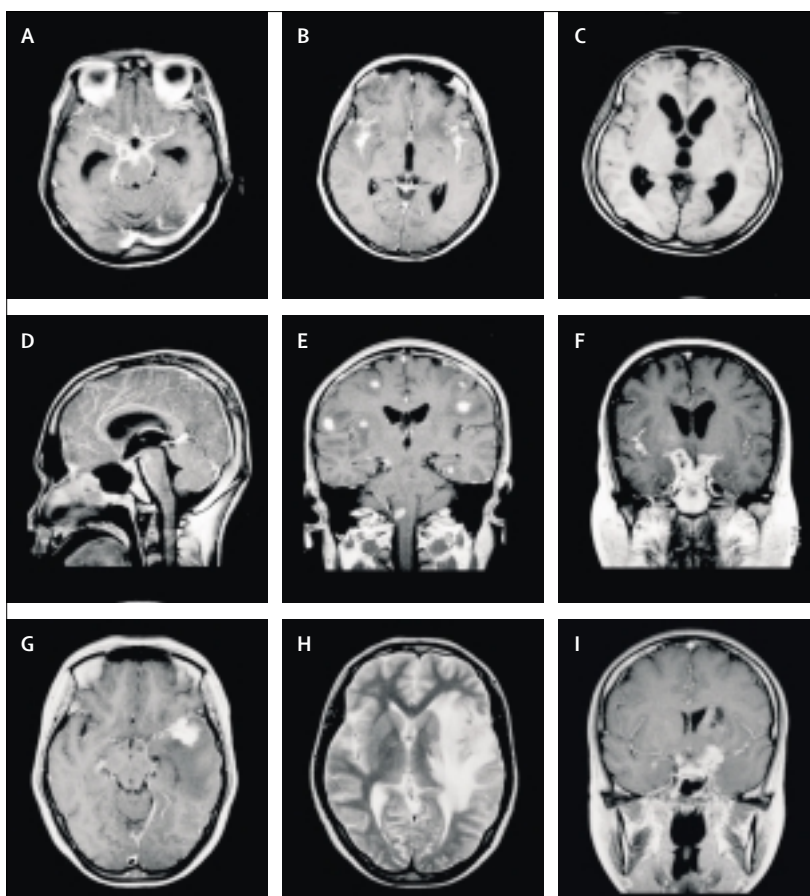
Common MRI findings in adults with tuberculous meningitis
